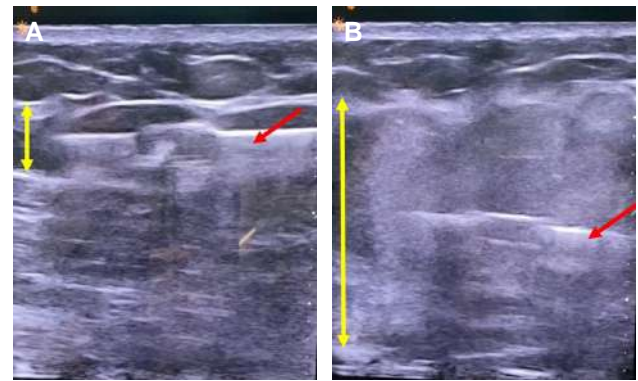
Static injection, migration, and equalization: Case 1. (A) Intraoperative real-time gluteal ultrasound is used to confirm the position of the cannula tip (red arrow) above the DGF and below the SGF. (B) The cannula (red arrow) is held stationary and fat is injected. The injected fat will result in a 3- to 4-fold increase the height (yellow double-headed arrows) of the deep subcutaneous space (between the SGF and the DGF) and a pressure-related migration of fat without the need to move the cannula to distribute the fat. The gluteus maximus muscle and the DGF are pushed down by this injection of fat. DGF, deep gluteal fascia; SGF, superficial gluteal fascia
